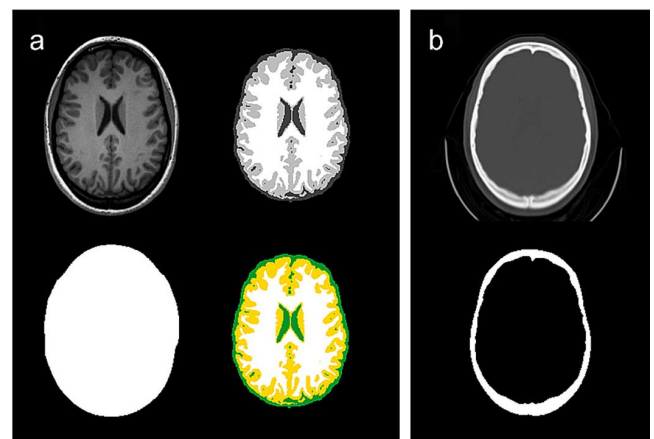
Generation of initial maps. a: From left to right and top to bottom, T1-weighted MRI, extracted brain image, outskin image, and its corresponding brain tissue segmentation. b: CT (top) and bone (bottom) images.
